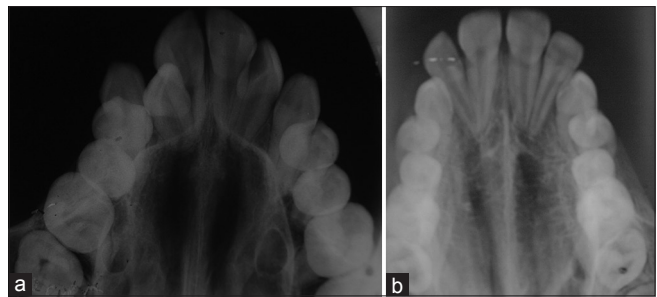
Pretreatment occlusal radiograph of (a) fan-type rapid maxillary expansion (b) Hyrax
